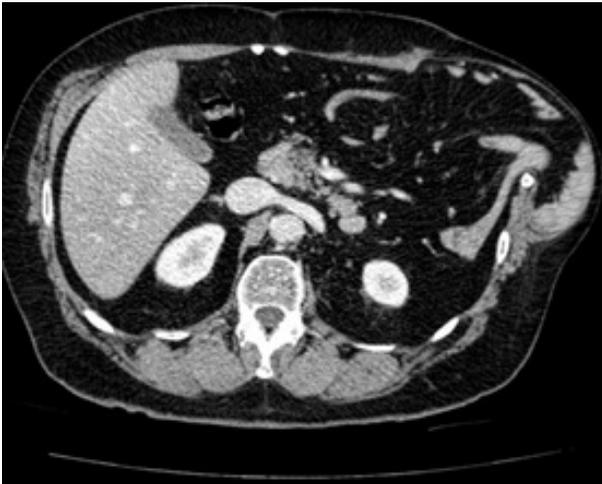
CT-scan, axial section: loss of integrity of the left abdominal wall with herniated bowels (left colic flexure)
